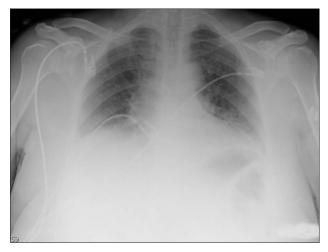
Chest roentgenogram showing no evidence of a foreign body
